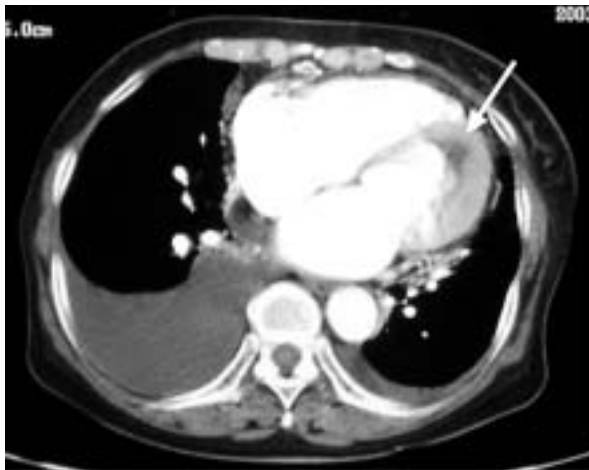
Thoracic enhanced computed tomogram
